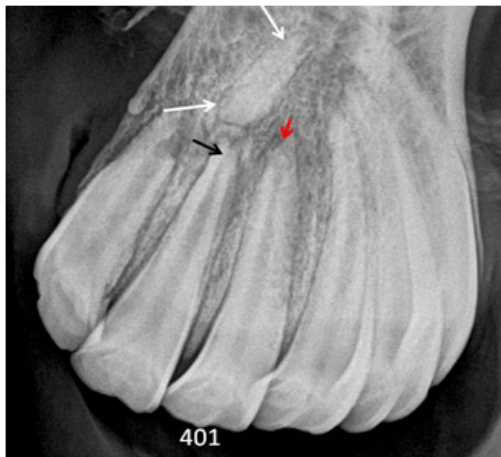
This radiograph is taken Feb. 8. 2012 showing rounded apices of 401 and 402 (red and black arrows). On the radiograph the fragment of 403 is projected axially due to oblique projection (between the 2 white arrows), is now very homogeneous in opacity, has unshaped edges and is significantly larger in transverse diameter due to cementosis in the periodontal ligament.
